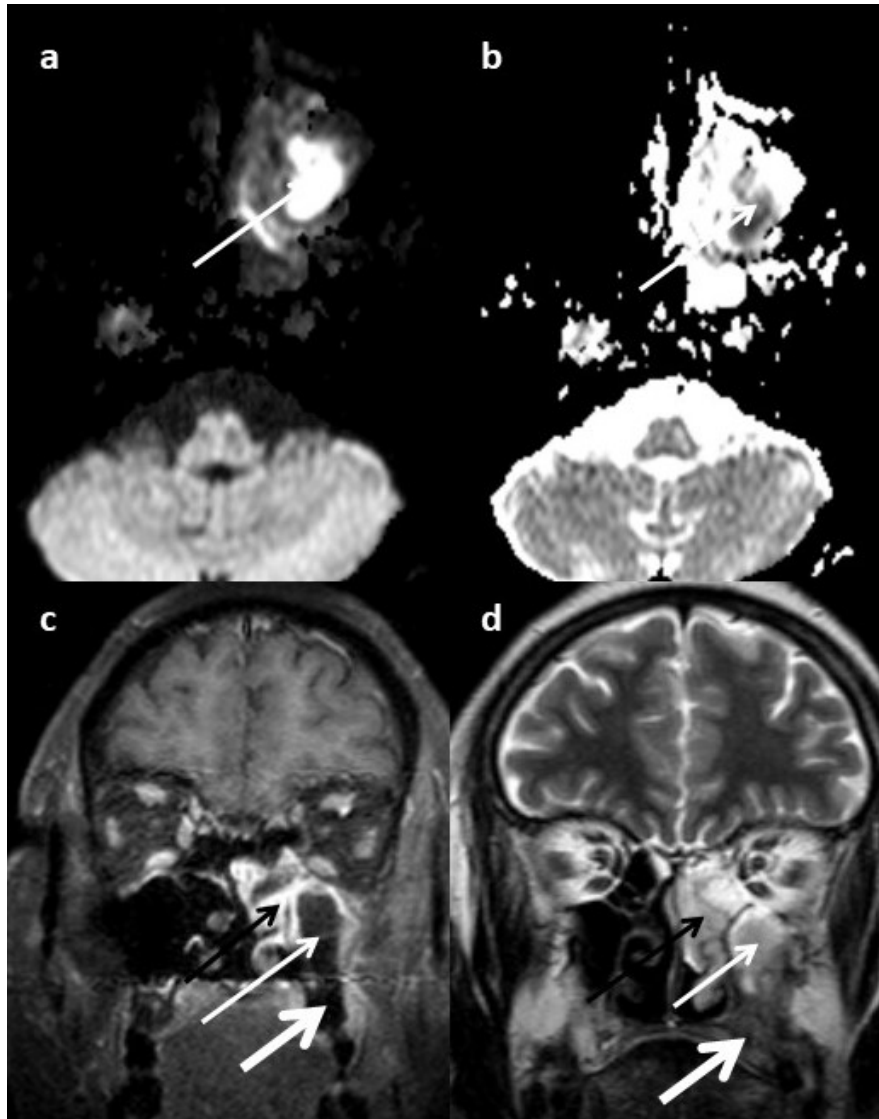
(a) DWI (b) ADC map (c) Contrast-enhanced coronal image and (d) T2-weighted coronal images at the level of maxillary sinuses show peripherally enhancing mucosal hypertrophy with central non-enhancing contents in the left maxillary sinus (thin arrow). These show diffusion restriction and are seen to extend into the left nasal cavity (black arrow) and the alveolar process inferiorly (thick arrow).
